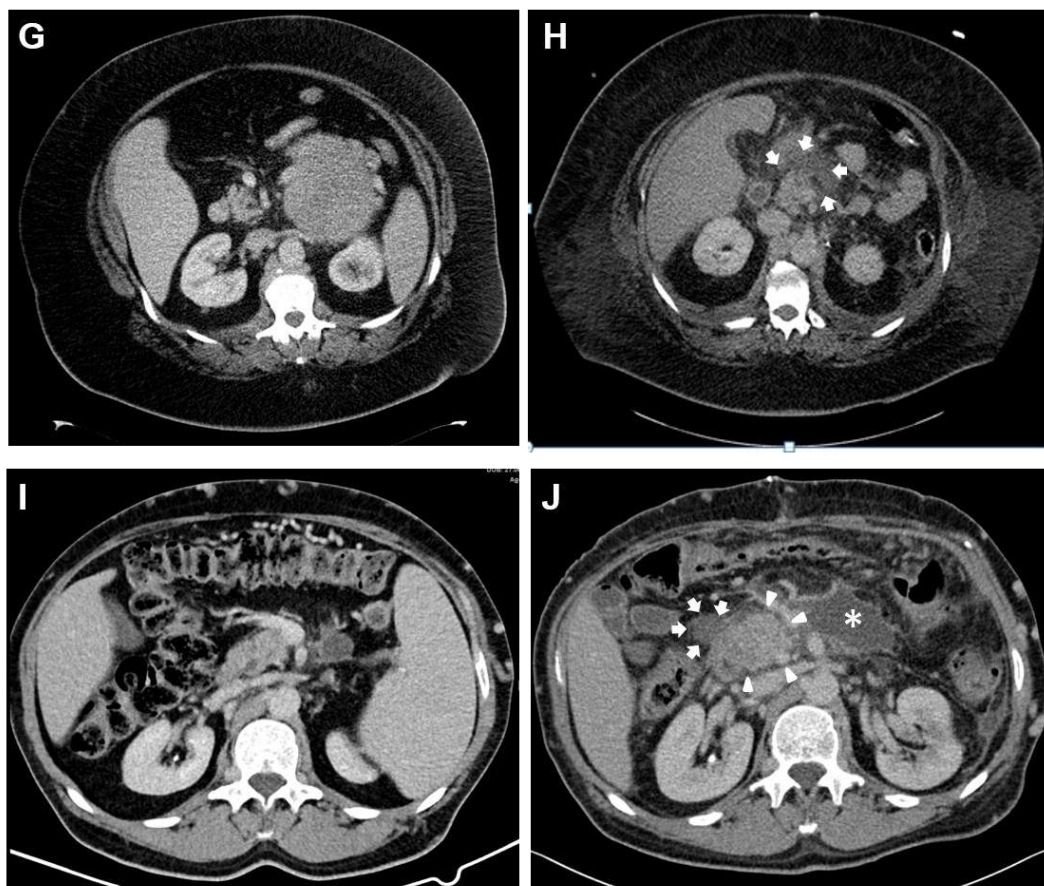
Comparison of preoperative (g, i) and postoperative (H, J) contrast-enhanced CT images of patients with PPAP undergoing distal pancreatectomy. (H) Patient with radiologic signs of PPAP with interstitial edema and peripancreatic fluid. (J) Patient with necrotizing PPAP with interstitial edema of the pancreas (white arrow heads), peripancreatic necrosis (white arrows), and a peripancreatic fluid collection (asterisk). (Images by courtesy of Markus W. Büchler MD, Heidelberg, Germany. Abbreviations: CT: computed tomography; PPAP: post-pancreatectomy acute pancreatitis).
